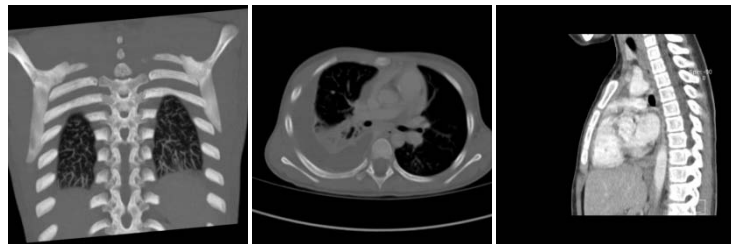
Sample chest CT images of a pediatric subject in the (a) coronal, (b) transverse and (c) sagittal views.
